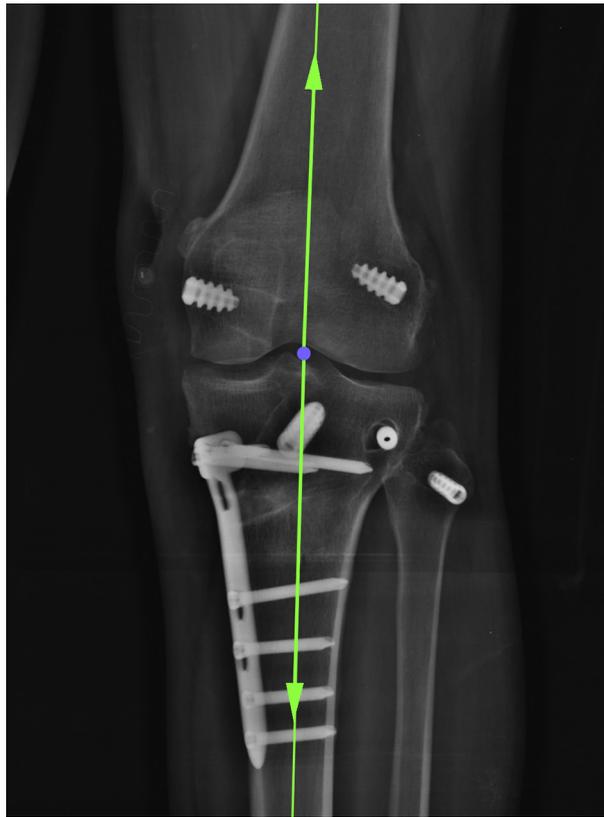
Radiograph showing fixation of the osteotomy with a medial plate, and posterior cruciate ligament and posterolateral complex reconstruction, without conflict between the tunnels and opening wedge.
